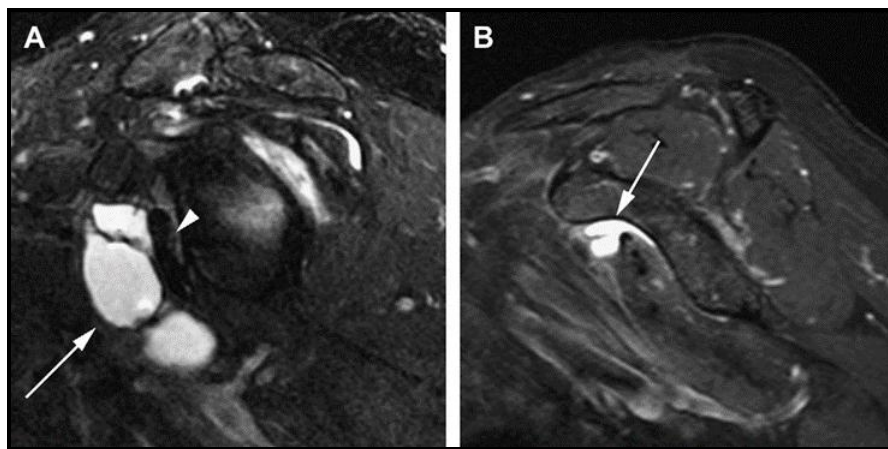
Subcoracoid bursa and superior subscapularis recess. Sagittal-oblique T2-weighted with fat-saturation MR images show (A) markedly distended subcoracoid bursa (arrow) located anterior to the subscapularis muscle and tendon (arrowhead). (B) Note that more medial to (A), the superior subscapularis recess (arrow) takes on a more saddle-bag like configuration over the subscapularis (*Cook et al., 2011*).
